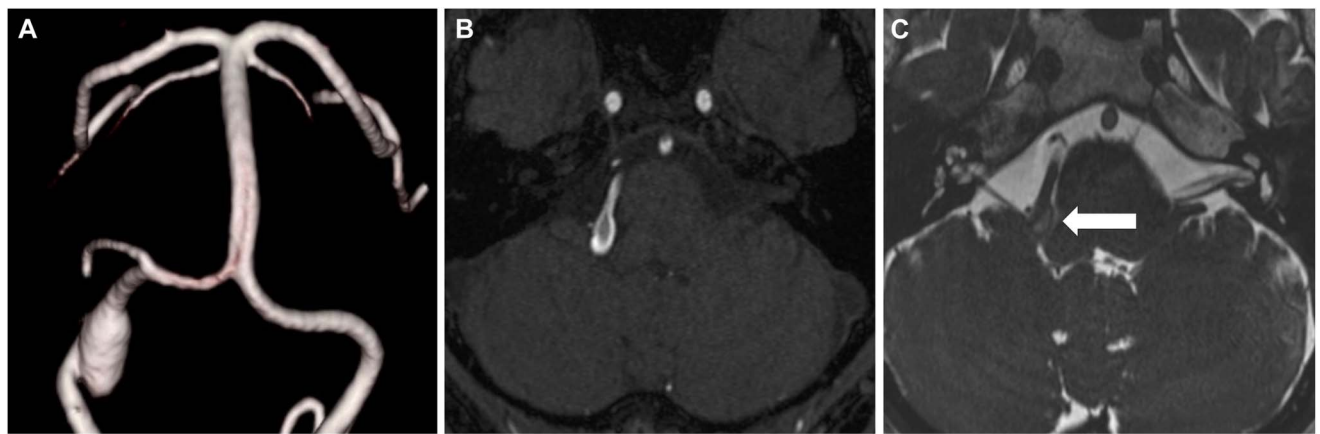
Initial cranial MR imaging. A, Three dimension and B, time of flight MR angiography showed an unruptured, fusiform, right vertebral artery aneurysm, with a maximum diameter of 10 mm. Fast imaging employing steady-state acquisition MR imaging demonstrated compression of the root exit zone of the right facial nerve by the aneurysm (C, arrowhead). MR, magnetic resonance.
